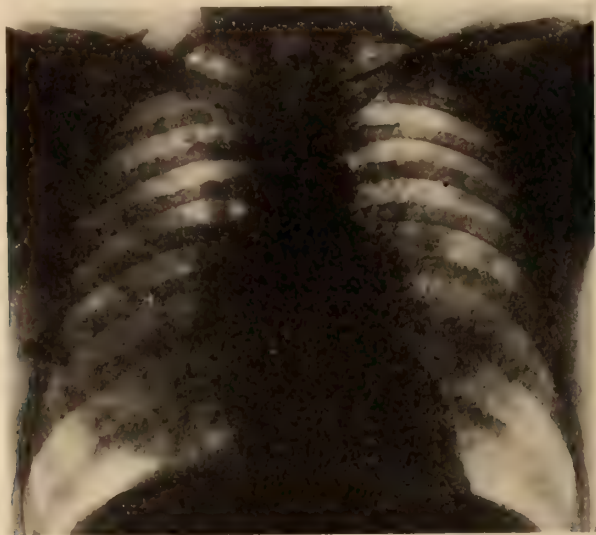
Roentgen examination of the chest on admission showing confluent peribronchial infiltrations.
